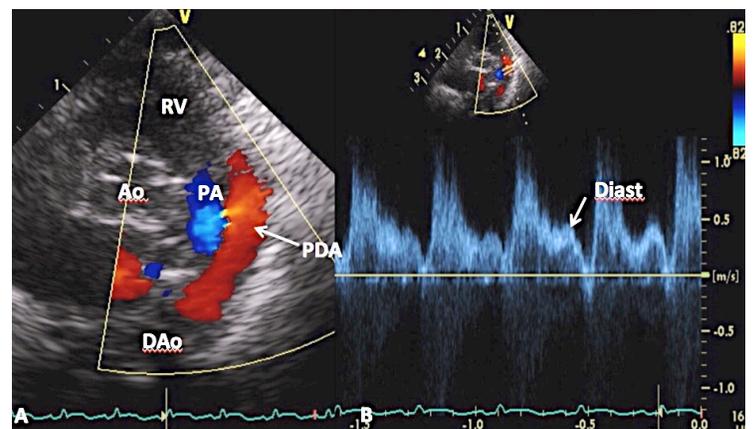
This figure is also similar to Figures 7 and 8 from a different preterm baby showing a large PDA. The estimation of pulmonary artery (PA) diastolic (Diast) (arrow) pressure may be similar to Figures 7 and 8 and is likely to be higher than those in Figures 7 and 8. Note laminar flow across the PDA. This along with low PDA Doppler velocity ( $< 0.5$  m/s) indicates near systemic PA pressures. Ao, aorta; DAo, descending aorta; RV, right ventricle.
